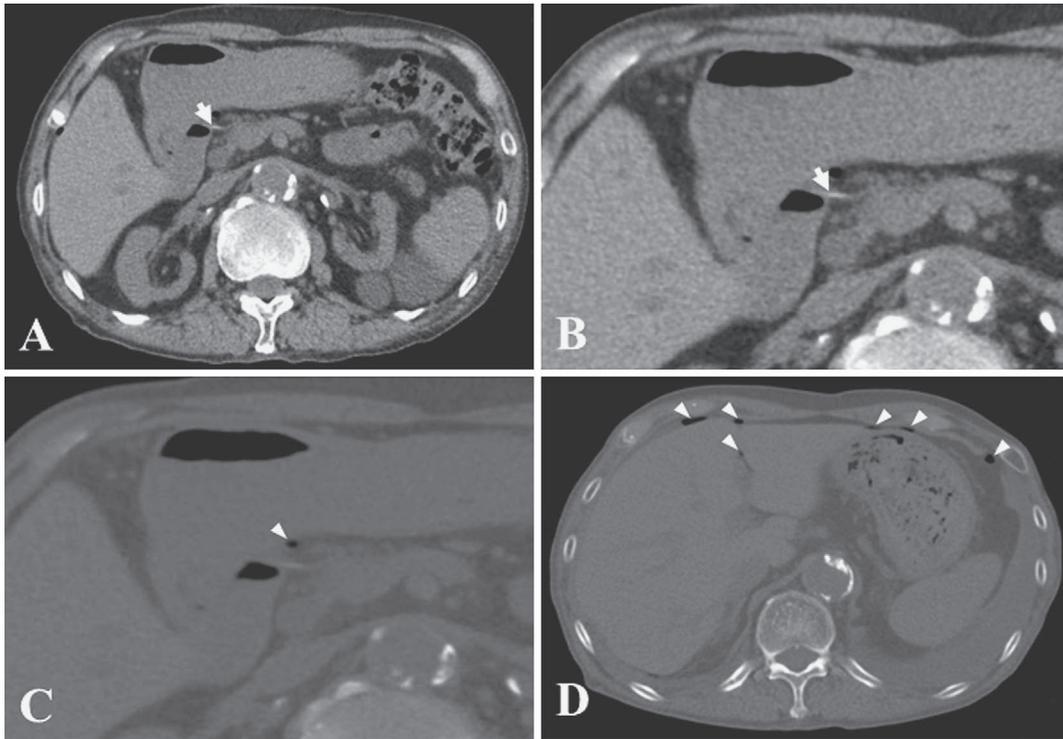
The findings of abdominal CT scan. An abdominal CT scan showed a linear fish bone in the duodenal wall (1A and 1B), air bubbles around the fish bone (1C), and multiple air bubbles (1D) in the peritoneal cavity.
